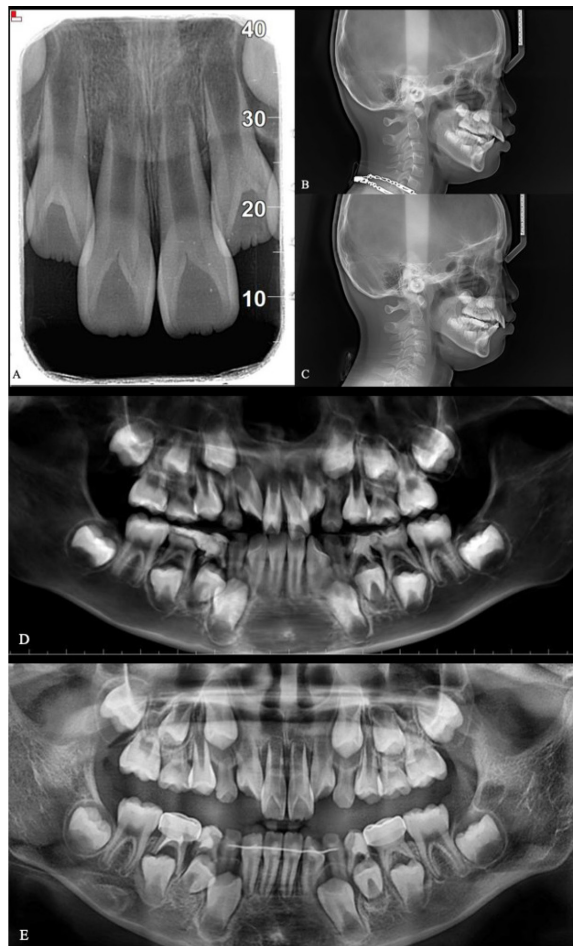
Post-treatment radiographs after a month; (A) Periapical radiographs after a month; (B) Pre-treatment lateral cephalogram compared with (C) Lateral cephalogram after a month; (D) Pre-treatment panoramic radiograph compared with (E) Panoramic radiograph after a month.
